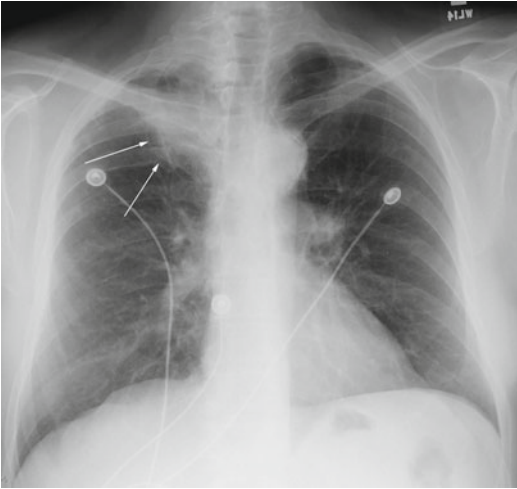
Frontal chest radiograph reveals density differences between right (*arrows*) and left lung apices, although exact borders of mass are hard to define
